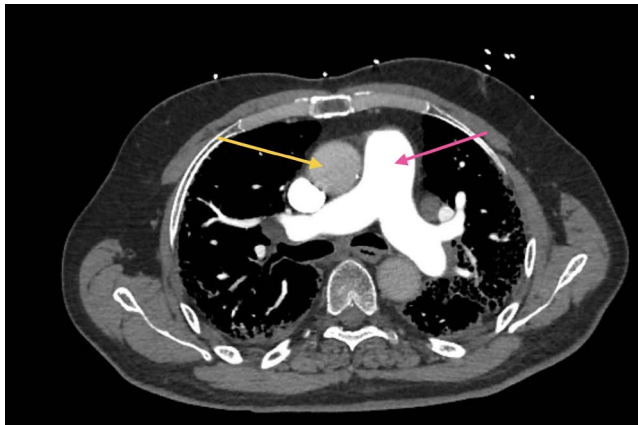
CT Chest with IV contrast, axial view, soft tissue window, at the level of pulmonary artery demonstrating enlarged pulmonary artery compared to aorta, which is highly suggestive of pulmonary arterial hypertension
